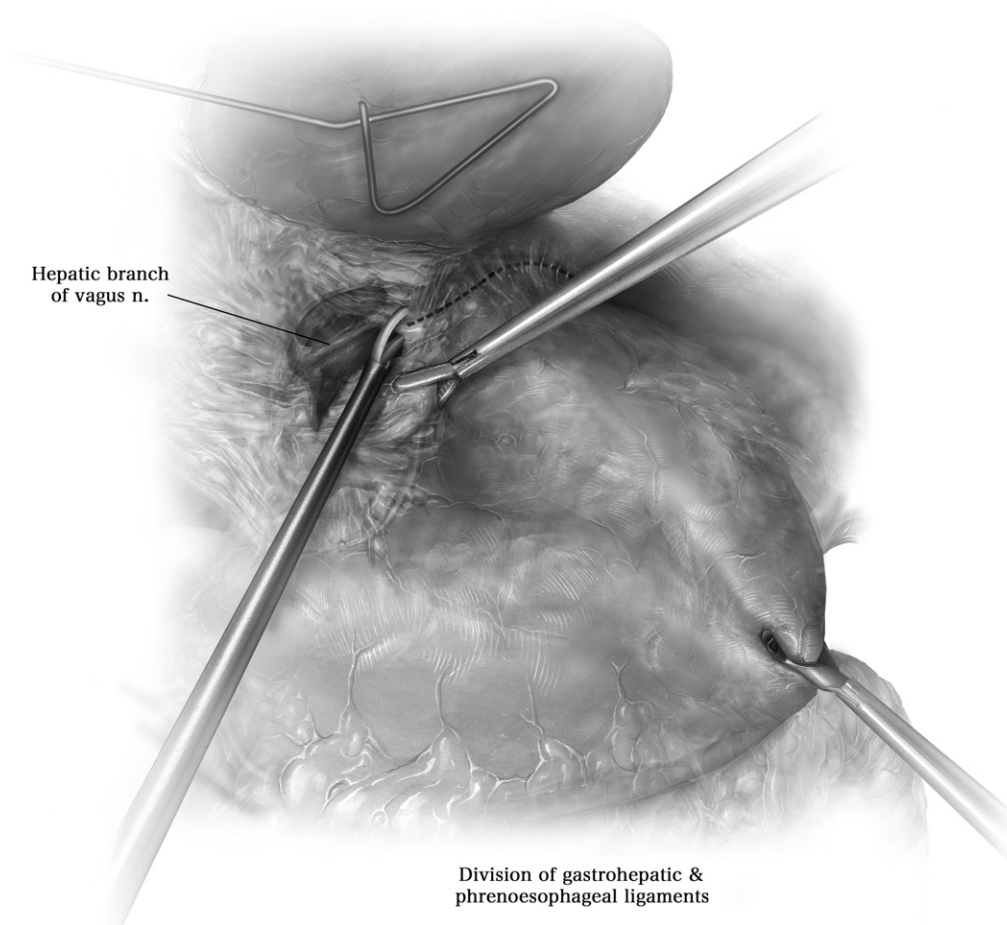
Exposure of the hiatus. The operation begins by elevating the left lobe of the liver anteriorly, using the fifth port for the liver retractor. The second port is used to place a grasper on the stomach, retracting it inferiorly and laterally such that tension is placed on the gastrohepatic and phrenoesophageal ligaments. An ultrasonic dissector or other cutting/sealing device is used to open the gastrohepatic ligament, exposing the retrohepatic liver as well as the right leaflet of the crus of the diaphragm. The hepatic branch of the vagus is preserved if possible, as are any aberrant or accessory vessels going to the left lobe of the liver. The phrenoesophageal ligament is likewise opened 1 to 2 cm below its insertion into the diaphragm.
